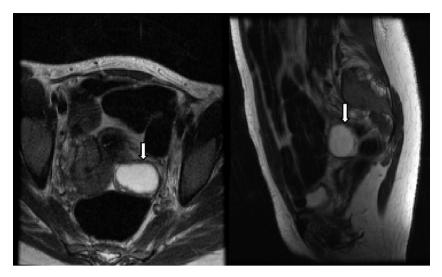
MRI pelvis axial T2 (A) and sagital T2 (B) obtained during the hospitalization. The arrows point to the ovarian teratoma.
